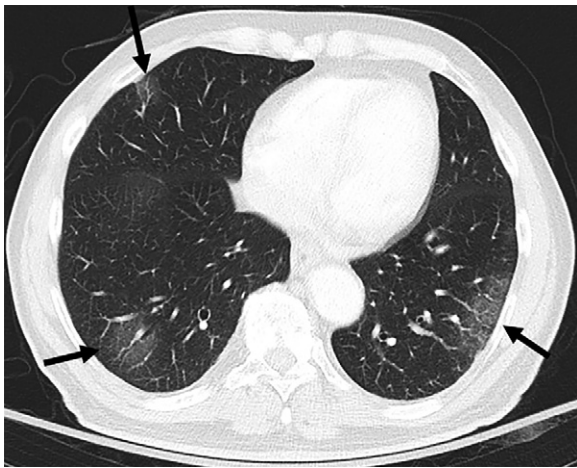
CT scan in lower lung areas in an 83-year-old male patient with coronavirus disease 2019 pneumonia and severe hypoxemia. Bilateral multifocal patchy ground-glass opacities with peripheral distribution are visible (arrows).
